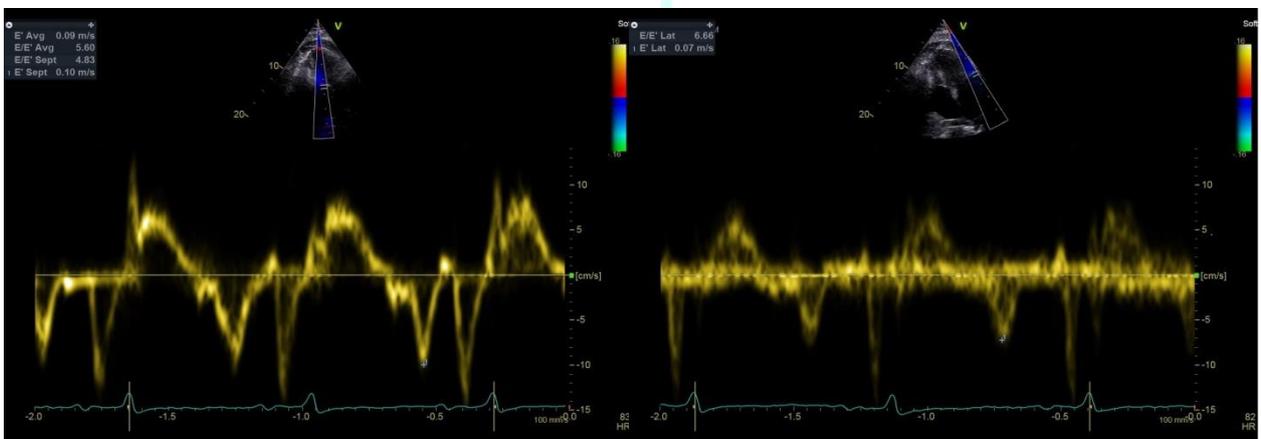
Transthoracic echocardiogram showing the increased tissue doppler imaging (TDI) E septal velocity more than TID E lateral wall velocity.
